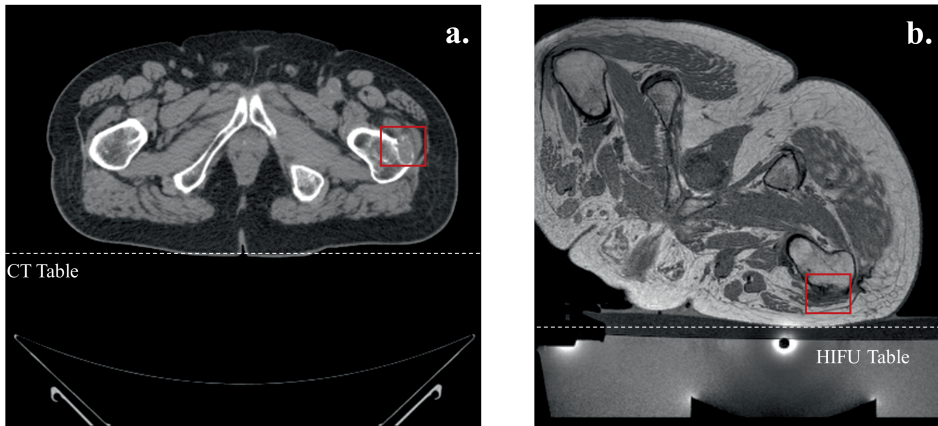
Scans from two image modalities of a patient with an osteoblastic metastasis in the femur. a.) CT image, b.) MR image acquired with the patient in treatment position. The transducer is submerged in an oil reservoir in the HIFU table, and the metastasis is within the red box.
